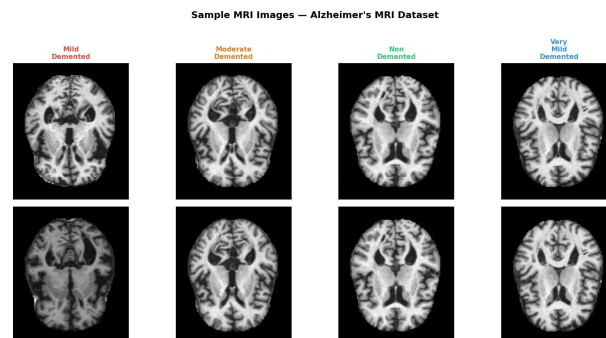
Representative axial brain MRI samples from the ADNI dataset. Each column shows two examples per class: Mild Demented, Moderate Demented, Non Demented, and Very Mild Demented (left to right).
